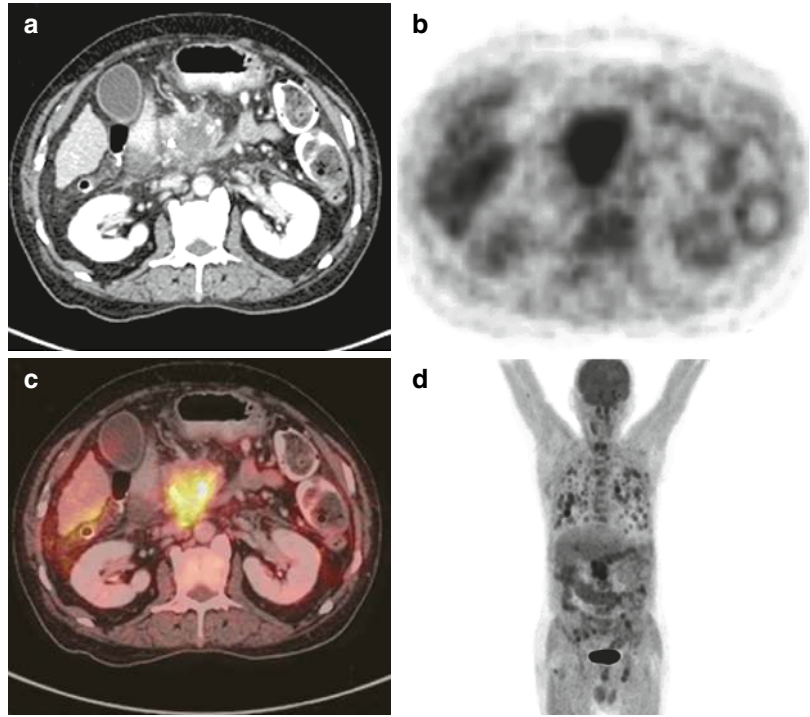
Diffusely bulky hypodense pancreas seen in the CT image a corresponding to the images b, c, and d suggestive of acute pancreatitis
